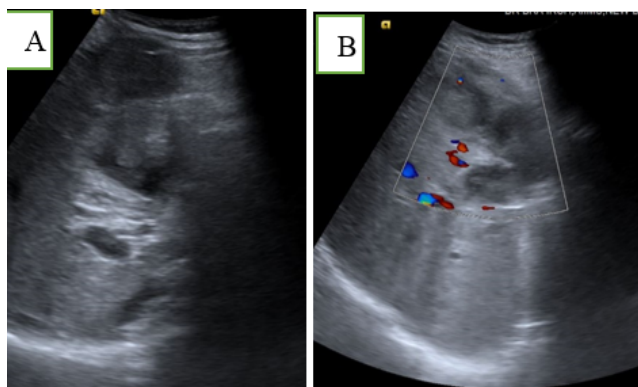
Gall bladder mass in a patient of RCC. Ultrasound image showing gallbladder wall thickening with echogenic mass (white arrow) occupying the lumen of fundus and body of GB (A) and show no significant internal vascularity (B)
